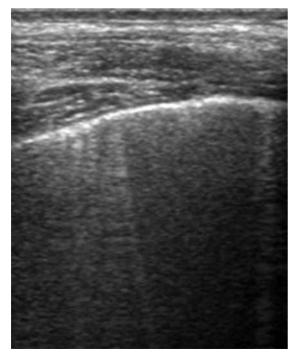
B-line in ultrasonography.
